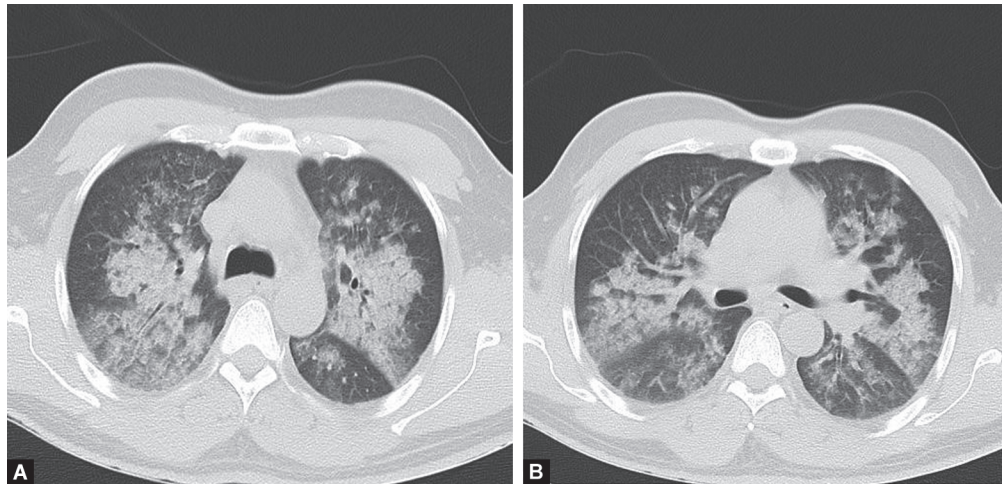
Chest X-ray showing patchy ground glass opacity (crazy paving pattern) in bilateral lung fields on postoperative day 2
